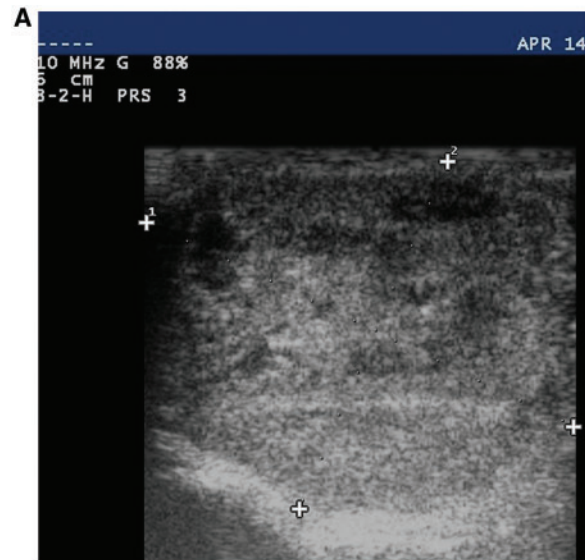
(a) Grayscale ultrasonography revealed a large well-defined echogenic mass. (b) Color Doppler sonography revealed hypervascularity of the scrotal mass.
